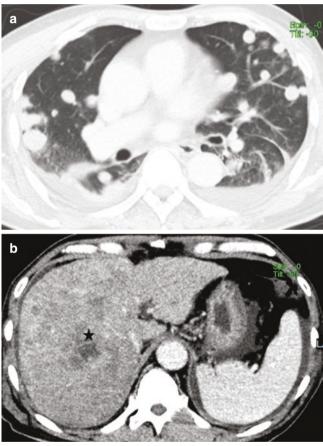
A 62-year-old man with pulmonary metastases from hepatocellular carcinoma. (a) Axial CT image shows multiple well-defined nodules of varying sizes in both lungs. (b) Contrast-enhanced axial CT abdomen shows a large hepatocellular carcinoma (asterisk)
